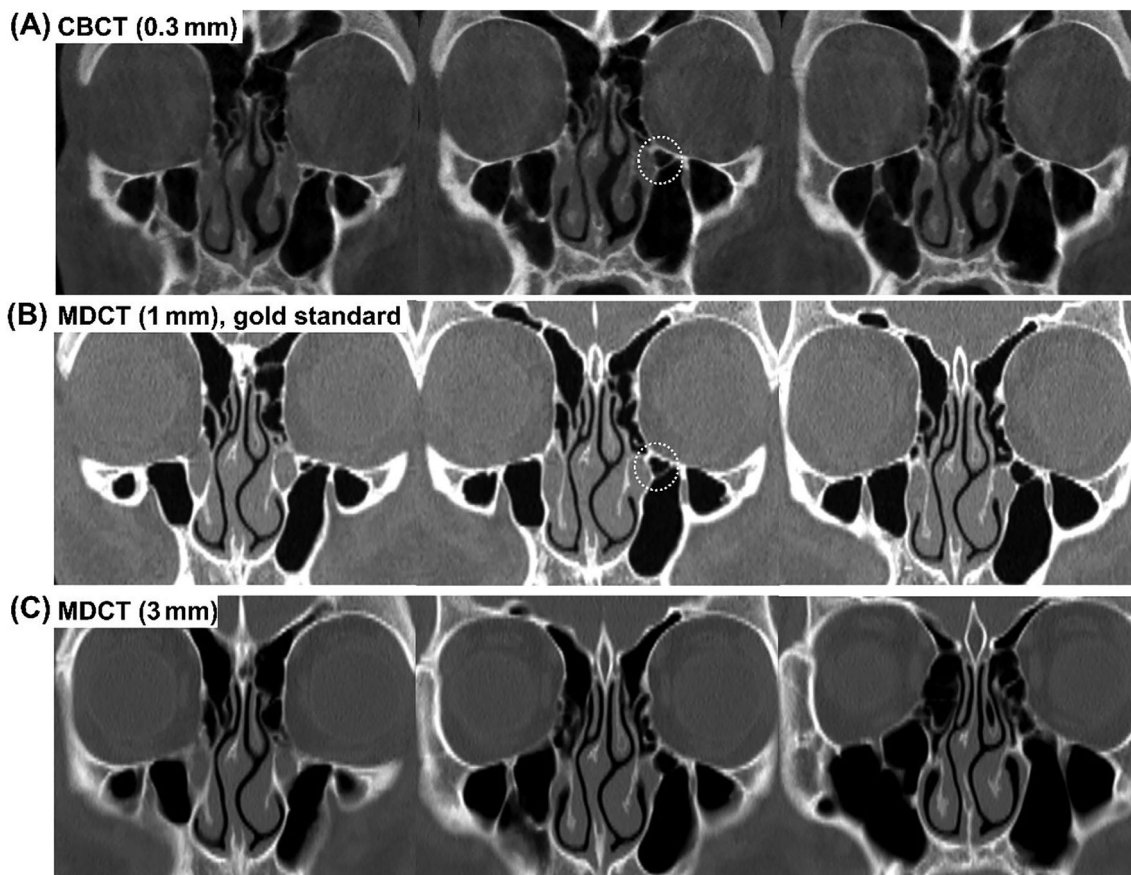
Haller cells (inside the dashed circle) on the left side are identified on (A) CBCT with 0.3 mm thickness and (B) MDCT with 1 mm thickness, but not on (C) MDCT with 3 mm thickness. CBCT, cone-beam computed tomography; MDCT, multi-detector computed tomography
